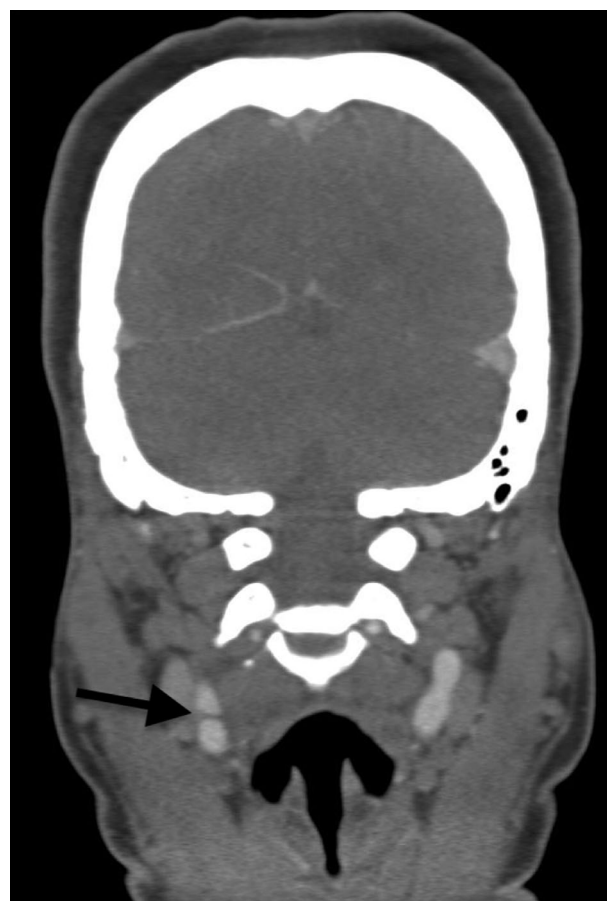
Computed tomography angiography of the head and neck demonstrating a carotid web at the origin of the right internal carotid artery, seen as a thin septate filling defect on coronal view (arrow)
